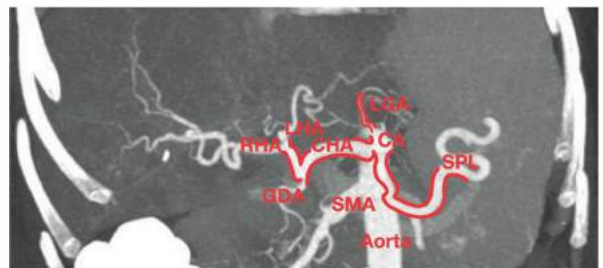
• CT angiogram showing classic arterial anatomy. The common hepatic artery (CHA) and splenic artery (SPL) come off of the celiac axis (CA). The CHA then gives off the gastroduodenal artery (GDA) and becomes the proper hepatic artery. This then divides into the right (RHA) and left (LHA) hepatic arteries. The aorta is also labeled, as is the left gastric artery (LGA) and the SMA.
